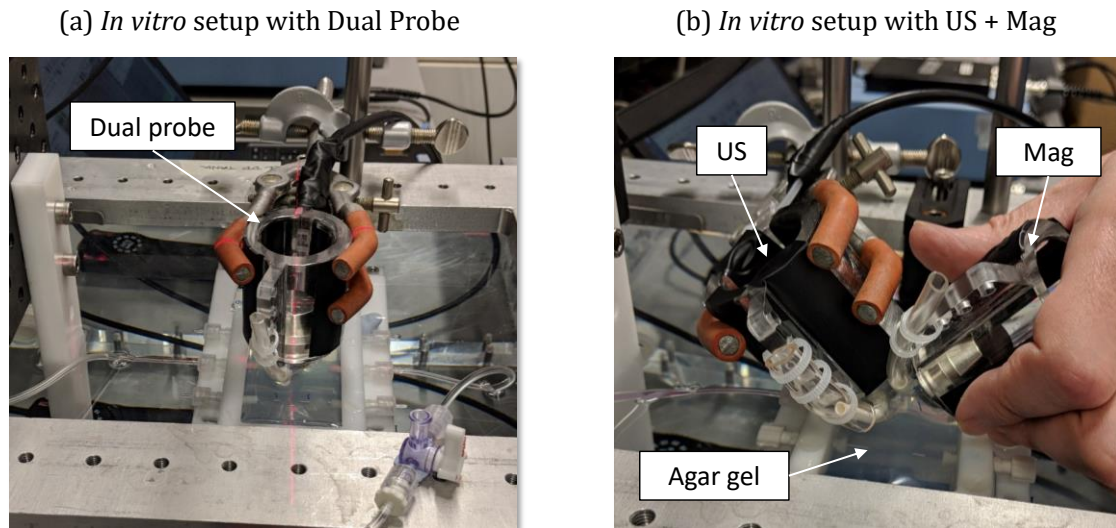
Photographs of *in vitro* ultrasound and magnet set-up for (a) the MAD with co-aligned fields compared to (b) the US + Mag group with separate field applications.
